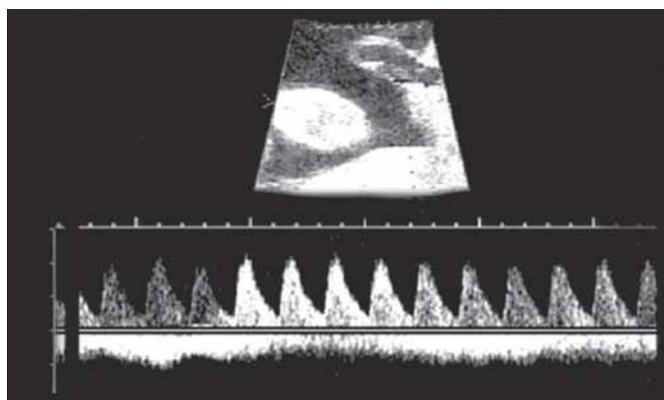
Doppler showing normal blood flow to normal fetus
